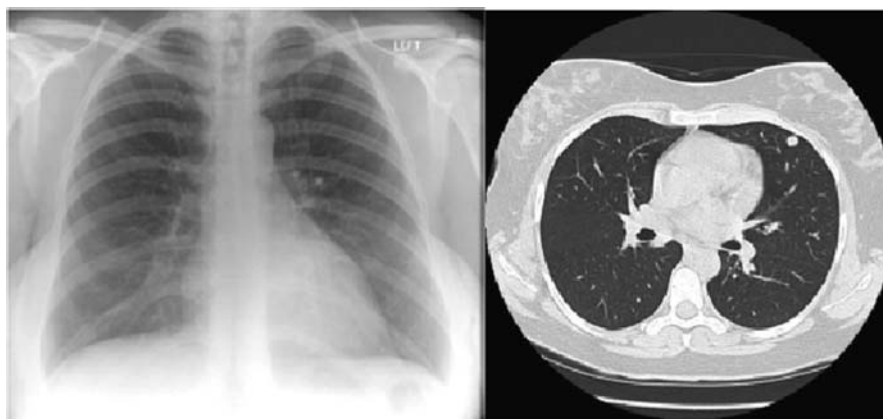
A clinical example with the CXR (reported as normal) and CT (with lung metastasis) from the same patient.
